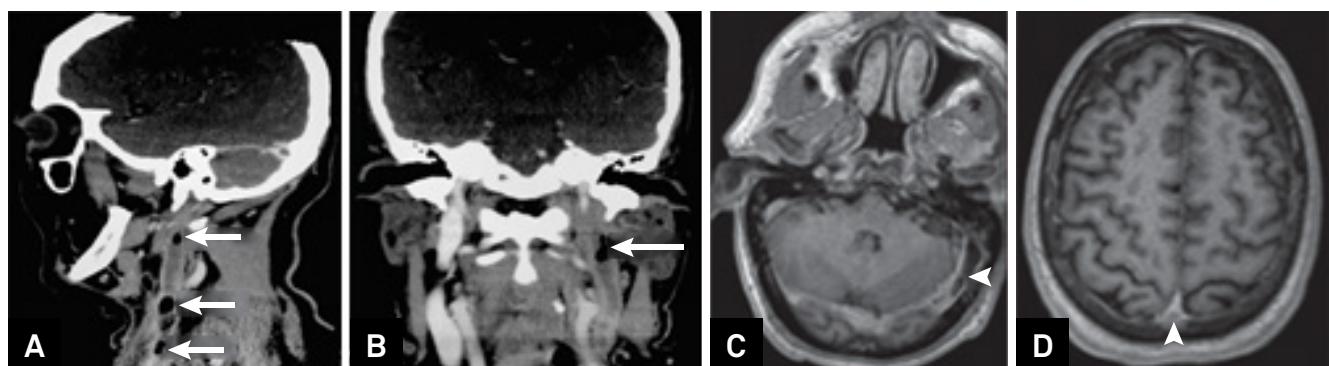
A/B: Sagittal (A) and coronal (B) contrast enhanced computed tomography of the neck revealing thickened and enhanced walls with filling defects in the left internal jugular vein (consistent with thrombosis). It is also possible to note air bubbles inside this vein (arrows). C/D: Axial T1-weighted images after contrast also showing filling defects (arrowheads) in the left transverse sinus (C) and in the superior sagittal sinus (D) compatible with cerebral venous thrombosis.
